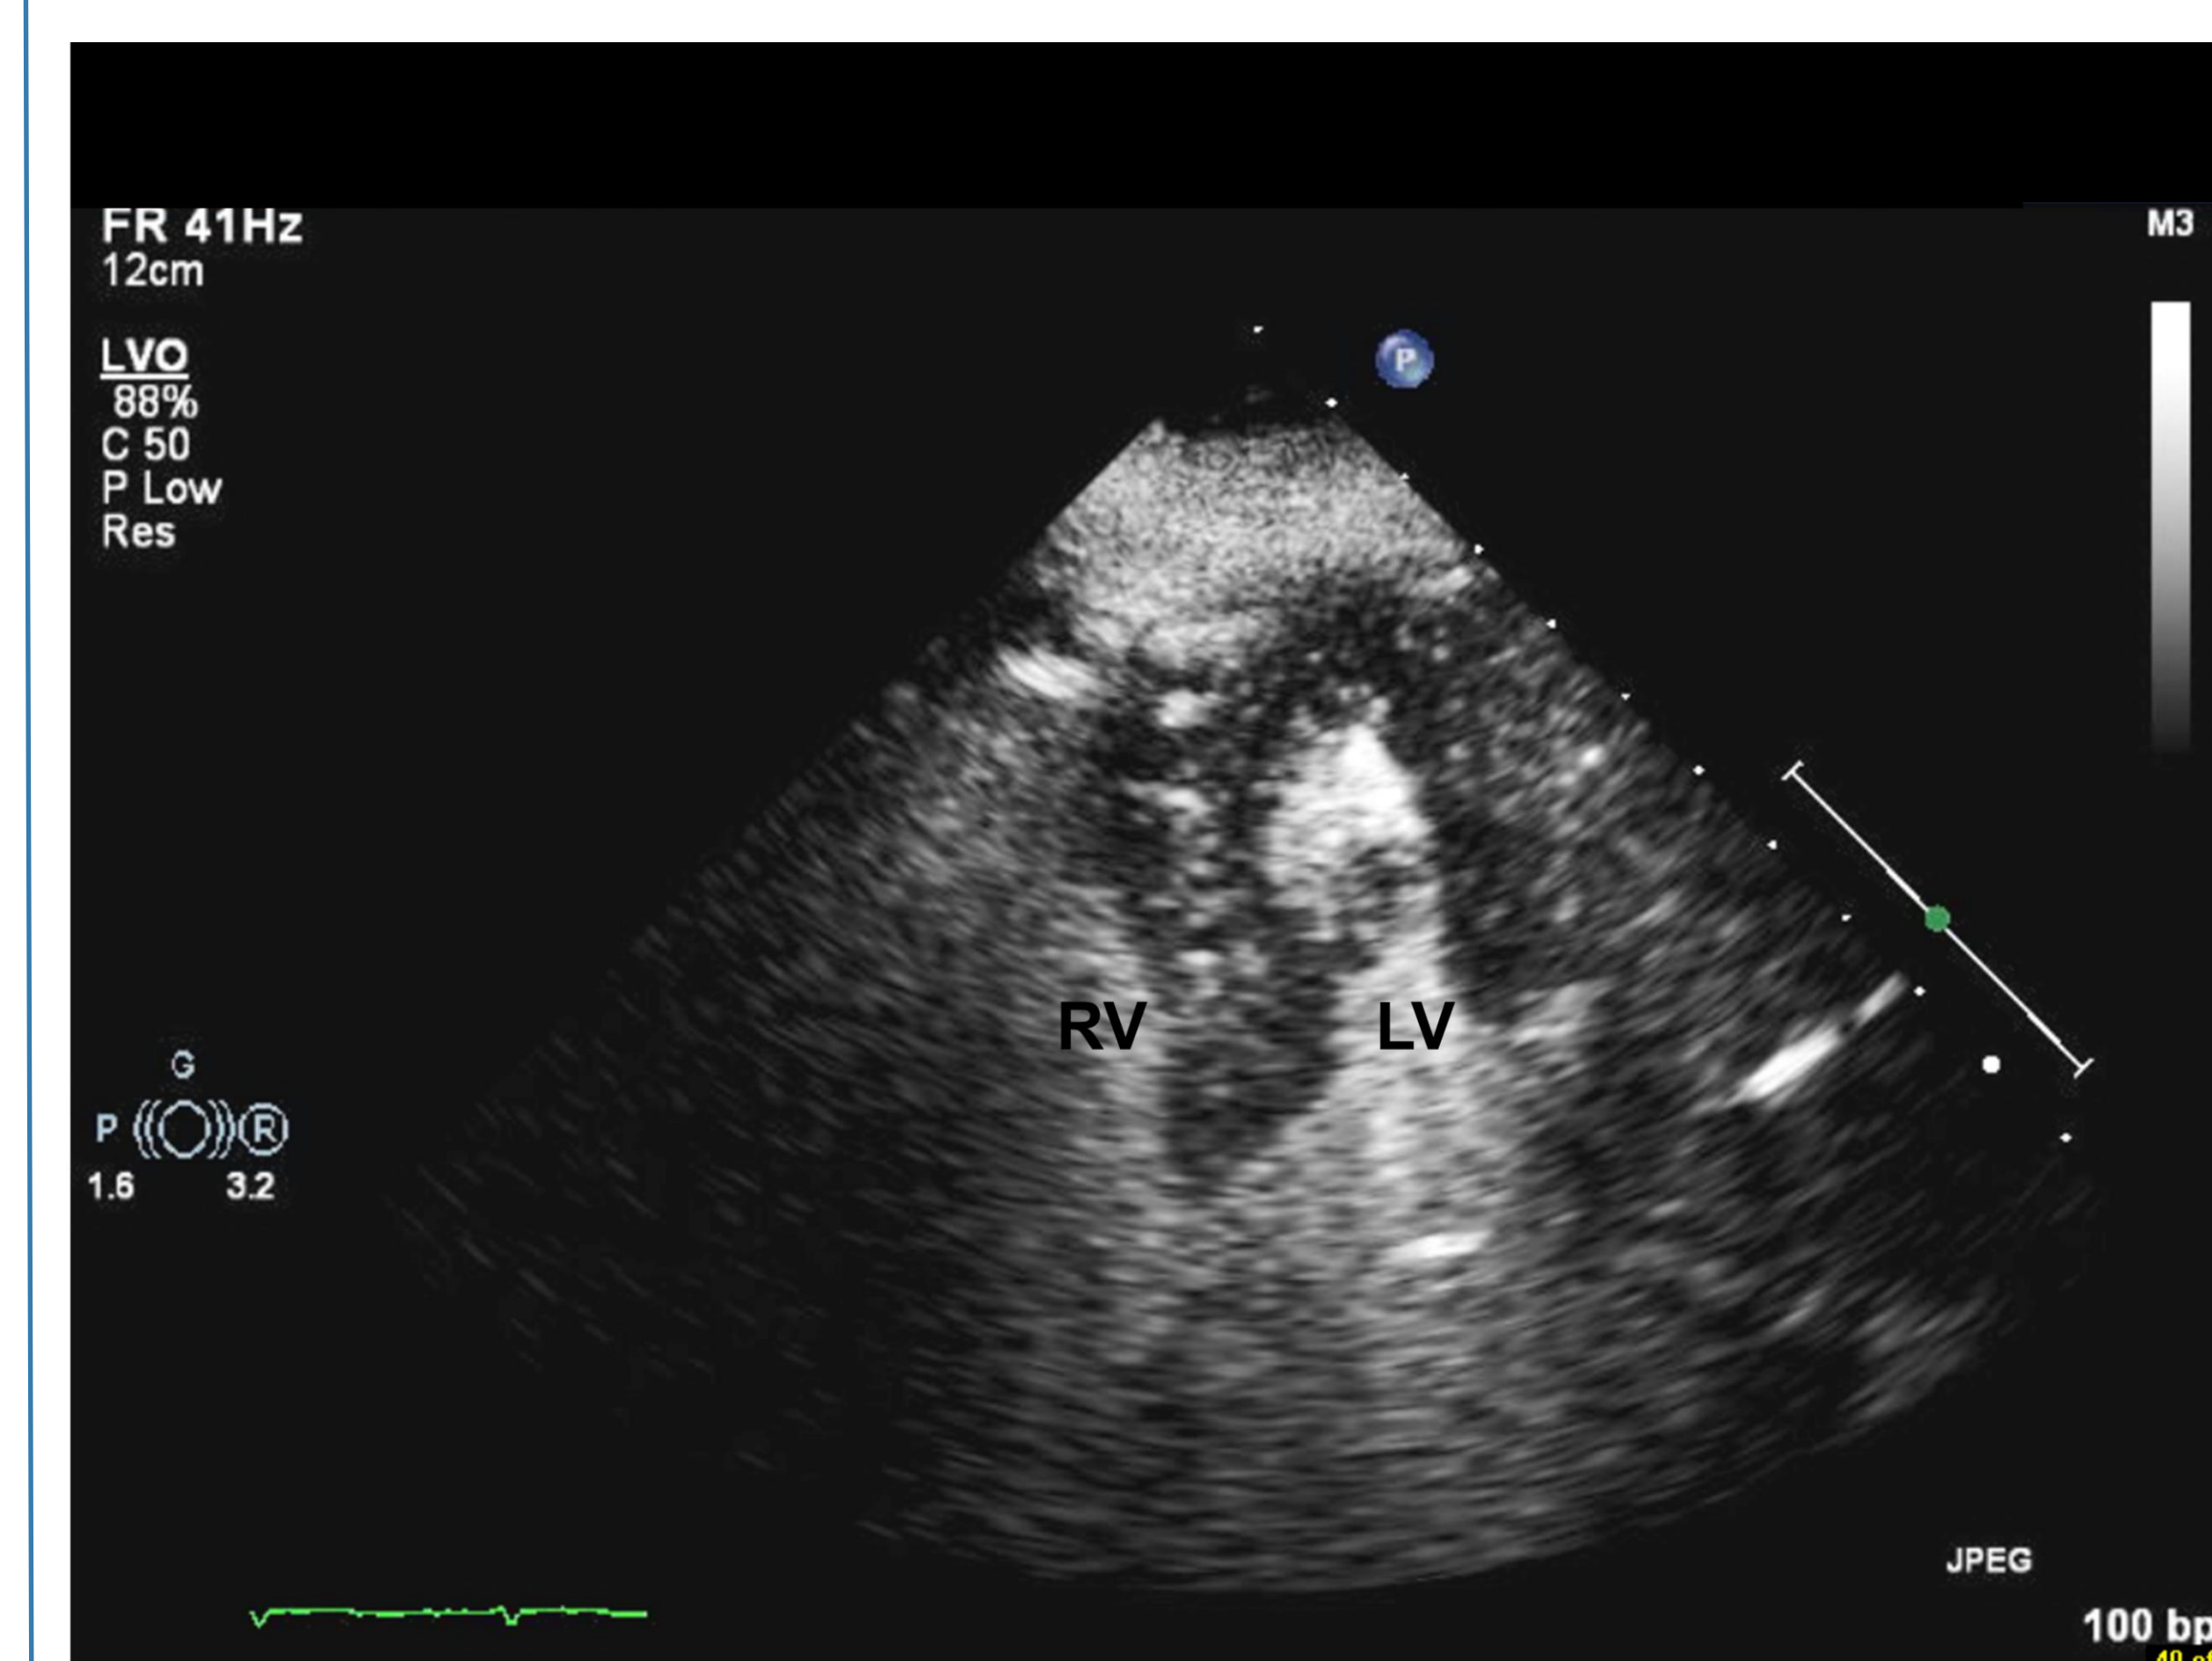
Contrast echocardiogram demonstrating contrast enhancement in the mass similar to the adjacent myocardium, which would be in agreement with the diagnosis of a tumor.
